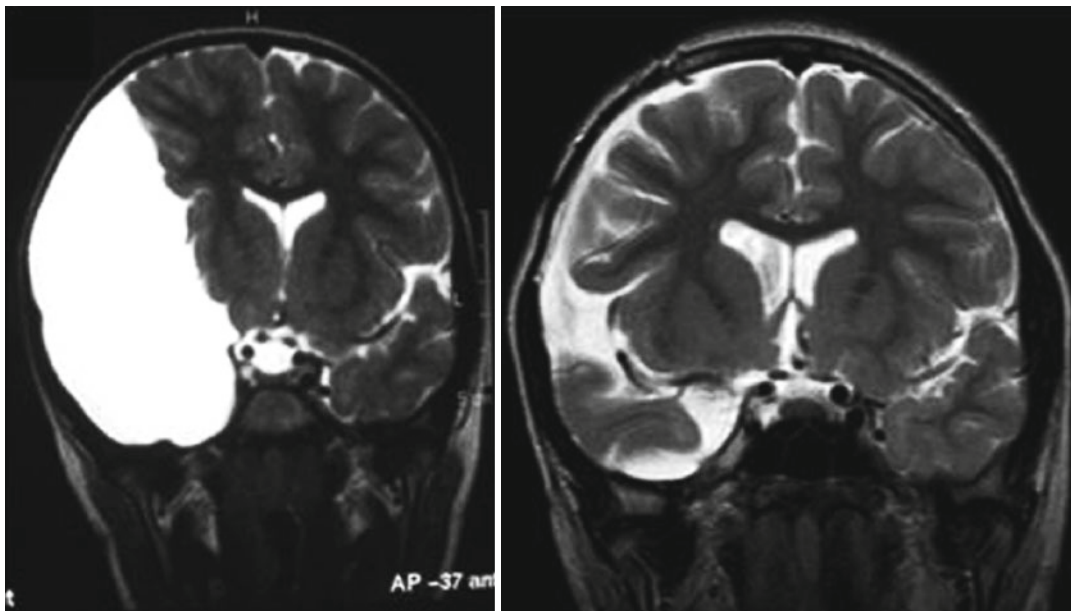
Preoperative (*left*) and postoperative (*right*) coronal T2w MRI images of right Sylvian arachnoid cyst. Brain re-expansion and cyst's volume reduction after
